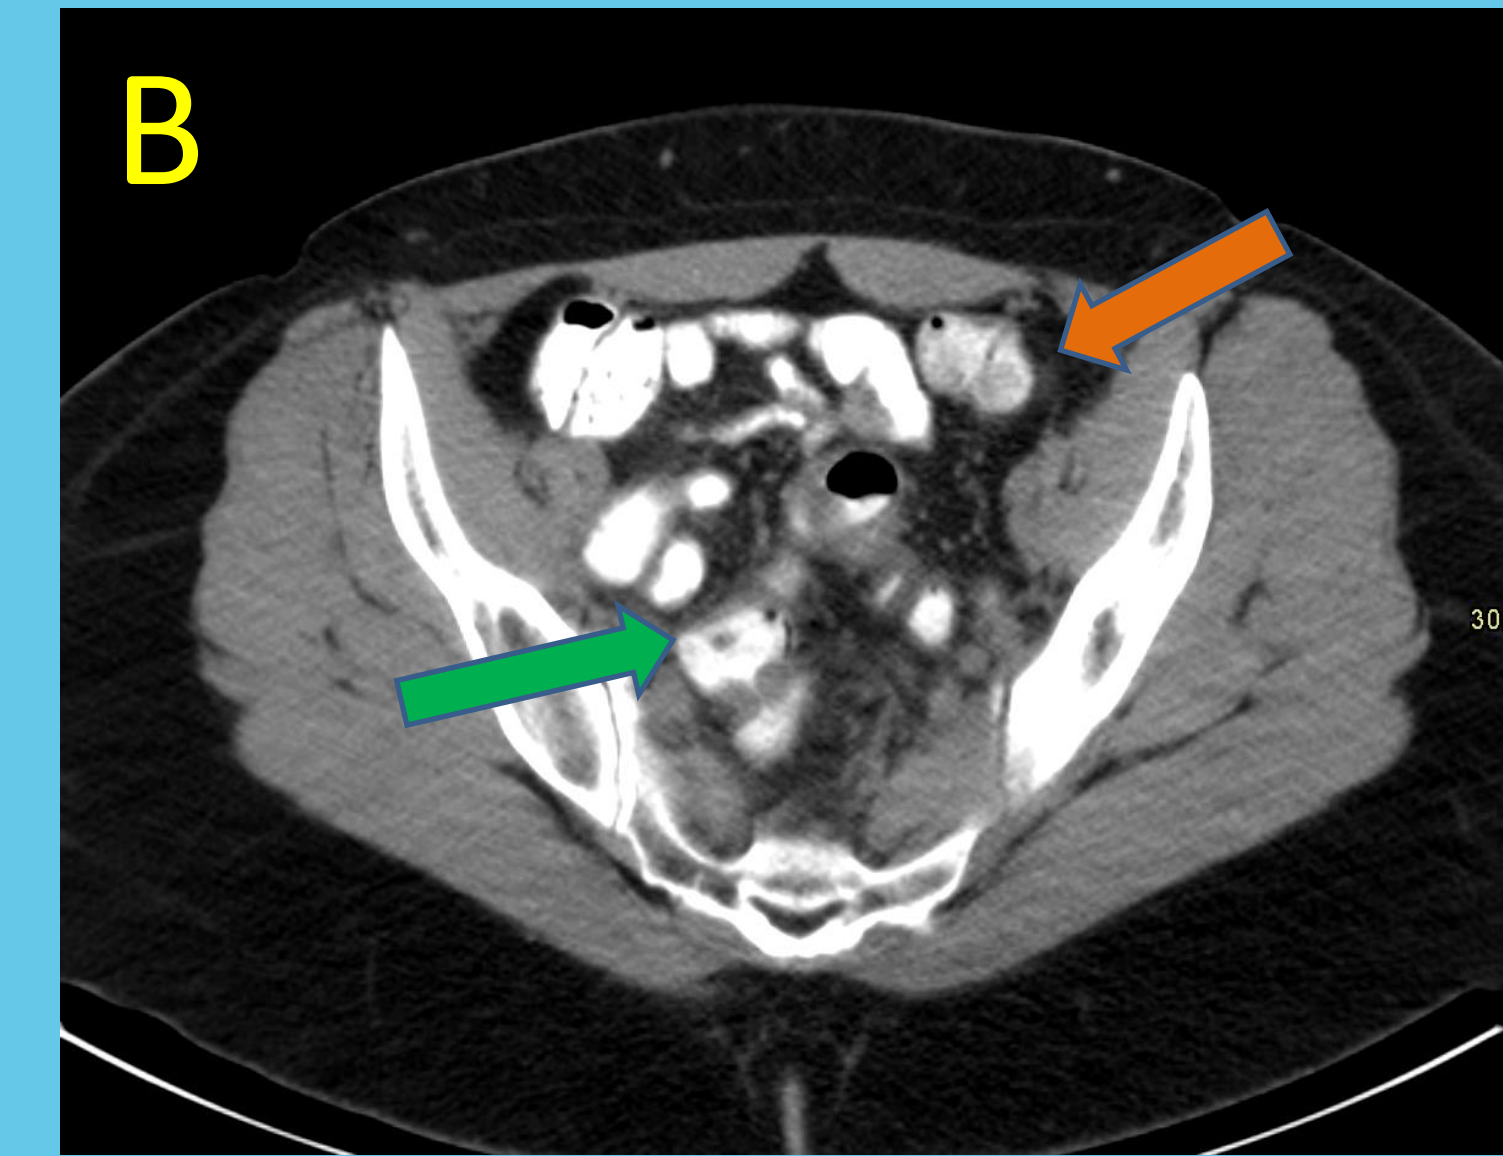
CT Abdomen and pelvis with oral contrast that was taken prior to oncologic interventions in 2015 with a green arrow pointing to normal distal ileum for comparison.
